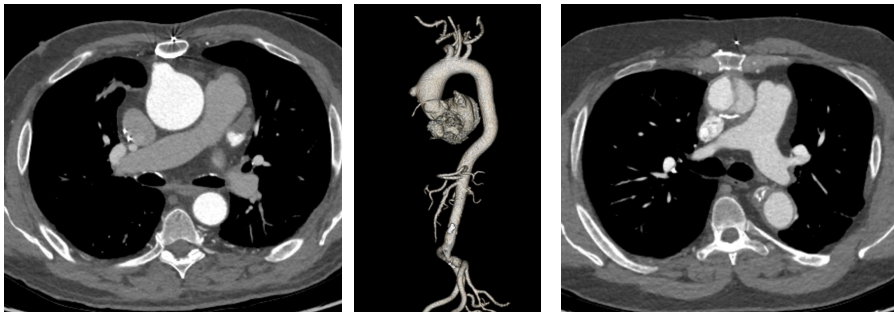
(A) CT scan of patient 1's pseudoaneurysm. (B) 3D reconstruction of patient 1's aortic PSA. (C) Axial CT of patient 2's PSA.
